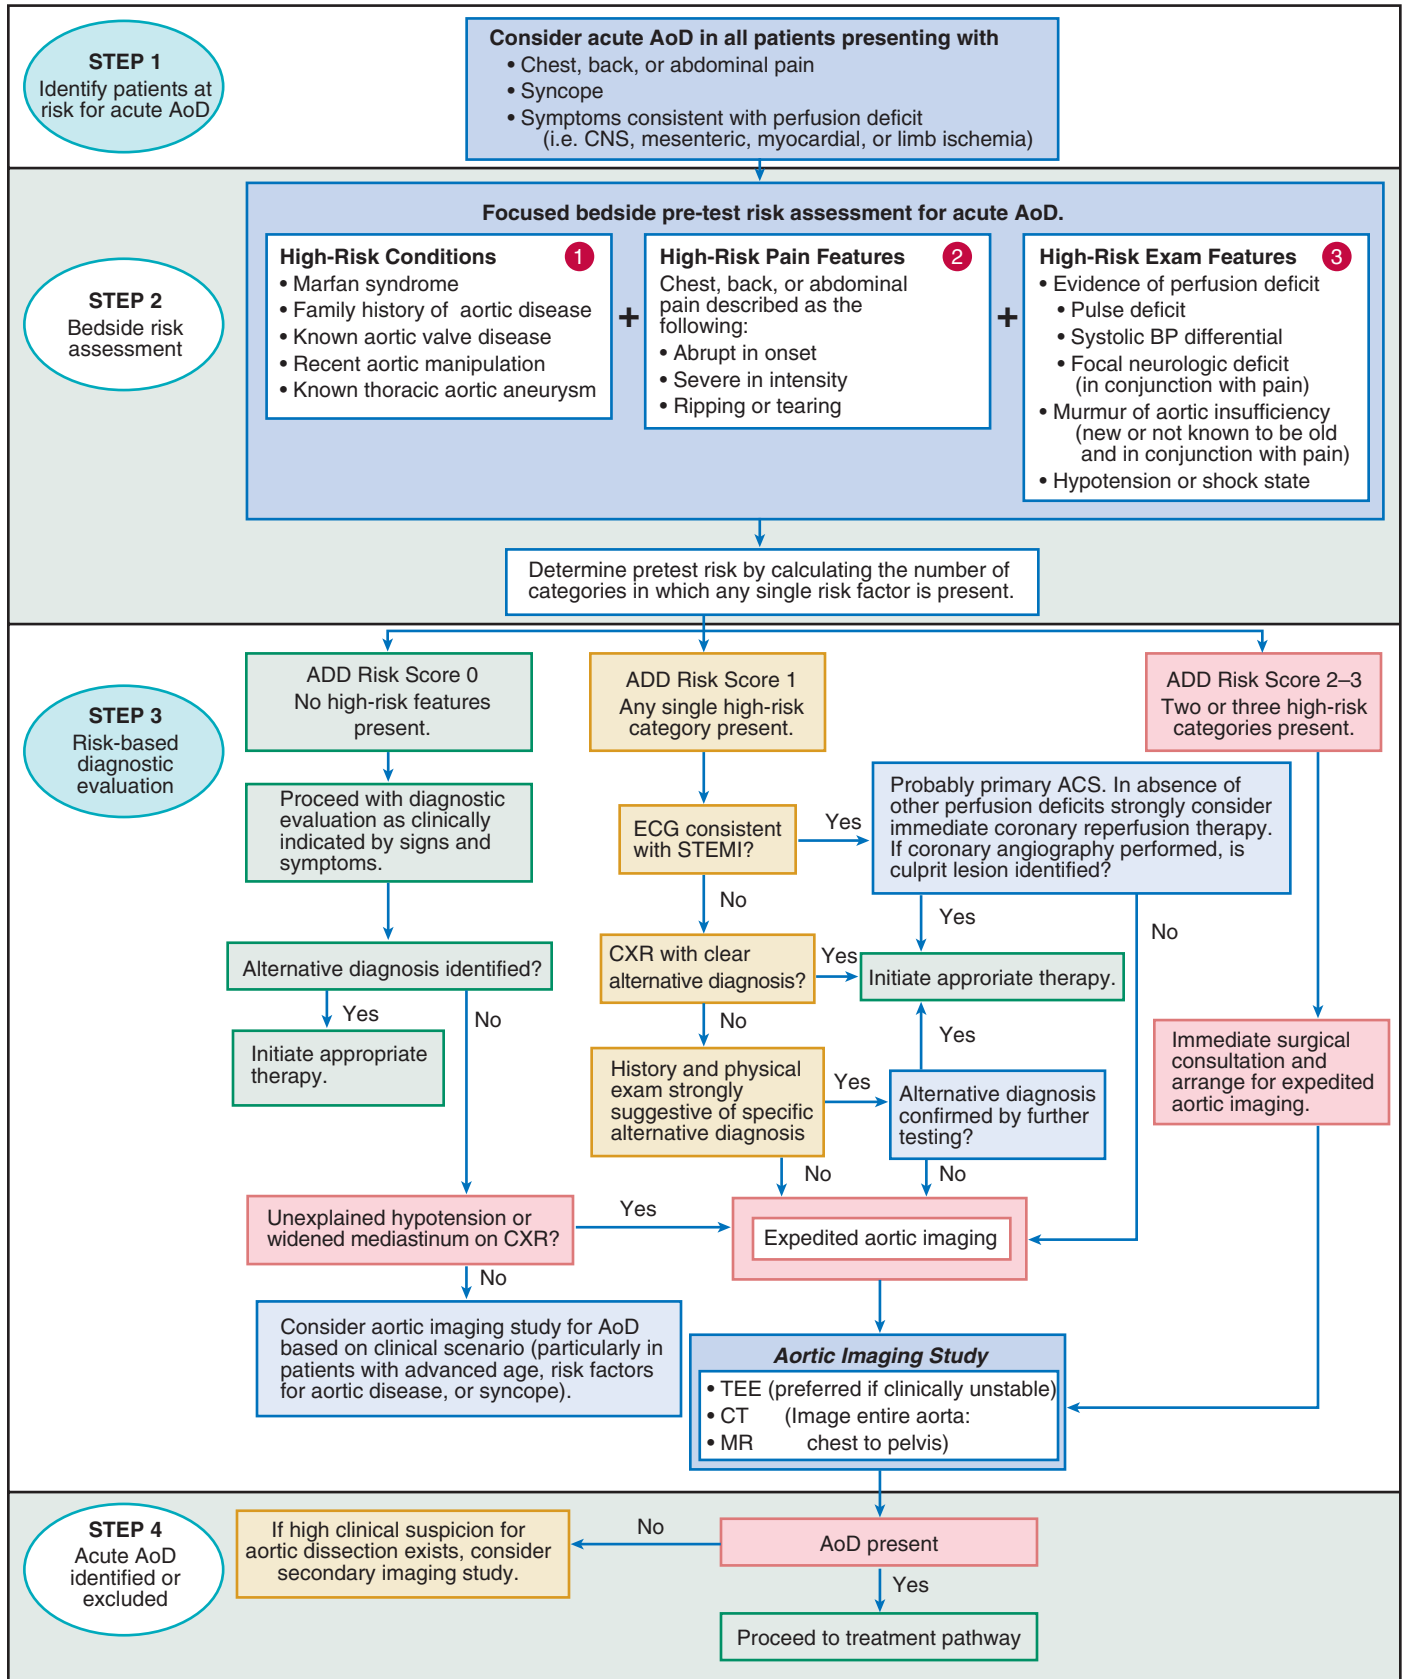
Evaluation pathway for aortic dissection (AoD). ACS = acute coronary syndrome; ADD = aortic dissection detection; BP = blood pressure; CNS = central nervous system; CXR, chest x-ray; STEMI = ST-segment elevation myocardial infarction. (Modified from 2010 American College of Cardiology/American Heart Association thoracic aortic disease guidelines.¹⁴ From Rogers AM, Hermann LK, Boohar AM, et al: Sensitivity of the aortic dissection detection risk score, a novel guideline-based tool for identification of acute aortic dissection at initial presentation: Results from the International Registry of Acute Aortic Dissection. *Circulation* 123:2213, 2011.)
